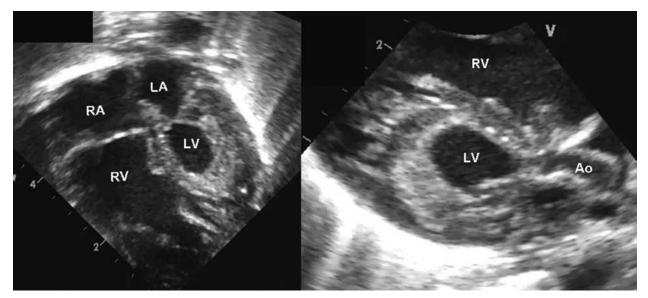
Hypoplastic left heart syndrome. Markedly hypoplastic left ventricle (LV) with dilated right ventricle (RV) is shown on the apical four-chamber view (*left)*. Small ascending aorta (Ao) is demonstrated on the parasternal long axis view (*right)*. LA, left atrium; RA, right atrium.
